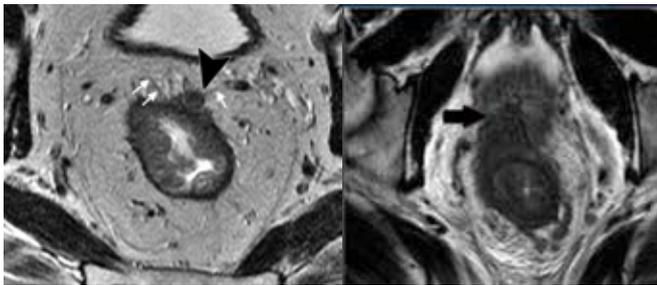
Infiltration of the MRF, peritoneum and adjacent organs can be assessed with axial T2-weighted images. a. Infiltration of the peritoneal reflection (arrowhead) between the bladder and rectum (arrows) (stage T4a). b. Infiltration of the prostate (arrow) (stage T4b).
